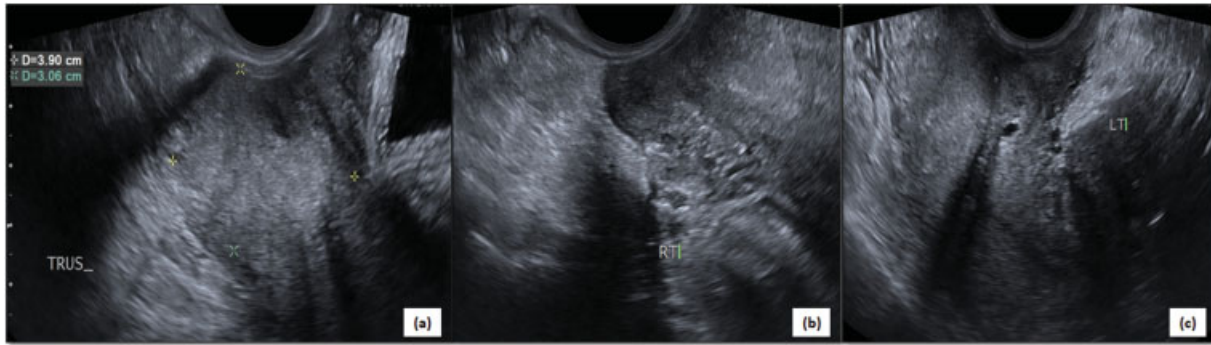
Transrectal ultrasound of carcinoma cervix—(a–c) Images of transrectal ultrasound of a lady with proven cervical malignancy show an irregular isoechoic mass replacing the normal stroma of posterior lip of cervix (callipers in a). The mass is infiltrating bilateral parametrium (b, c).
